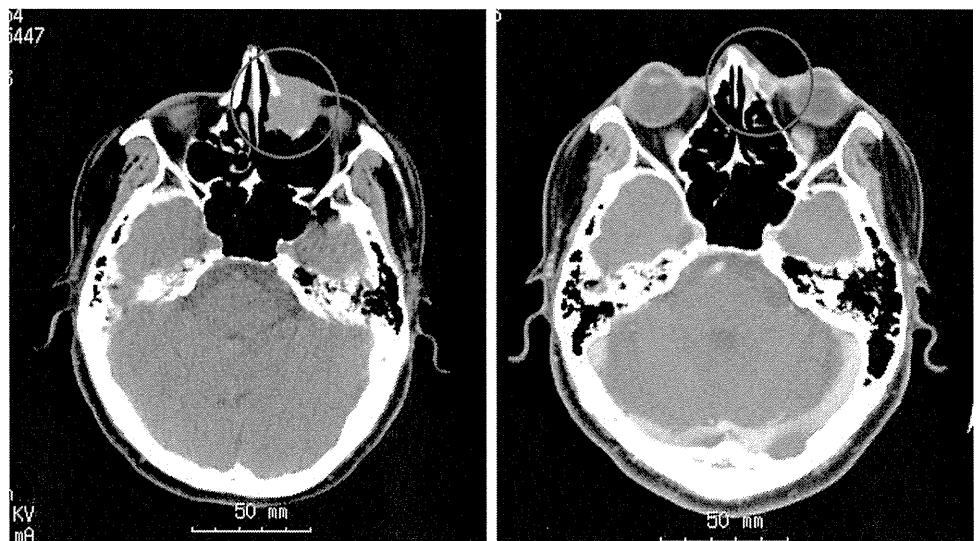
Case presentation (Patient 4). Before irradiation (*left*), left orbital tumor on CT shown by *red circle*. Six months later (*right*), the tumor disappeared
